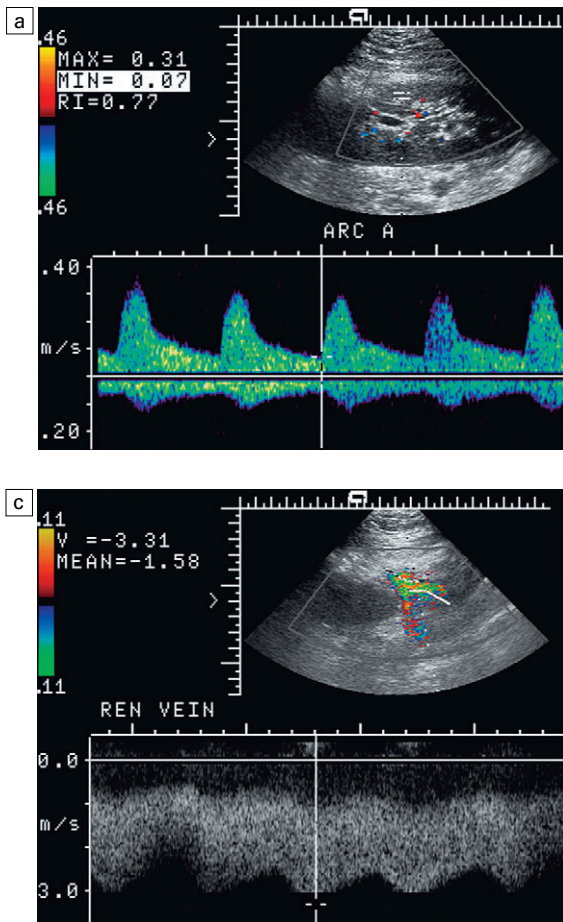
(a) Longitudinal colour Doppler image along the long axis of an intraperitoneal renal transplant with a spectral Doppler tracing of an arcuate artery. The arterial waveform shows a tardus parvus configuration indicating arterial inflow compromise. (b) The main renal artery at the hilum reveals a high velocity jet approximating 3 m s^{-1} . (c) Immediately adjacent to the main renal artery, the main renal vein spectral Doppler tracing also shows turbulent high velocity flow. This finding of high velocity, turbulent Doppler tracings in both artery and vein is due to torsion of the renal vascular pedicle and resultant kink of the main artery and vein. Fortunately this was only partial torsion of the kidney and was corrected with nephropexy. Intraperitoneal torsion of a transplant kidney has been reported to result in infarction.
